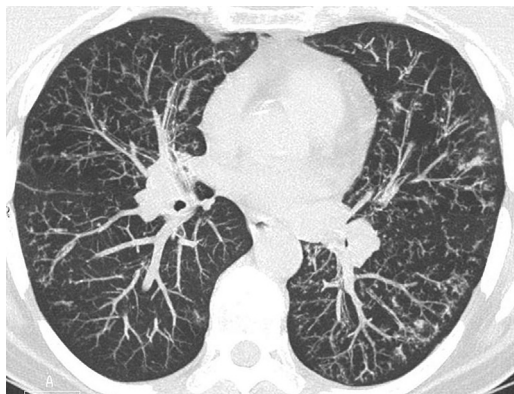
Mycobacterium avium*-intracellulare bronchiolitis. CT shows diffuse tree-in-bud opacities by NTM infection.
